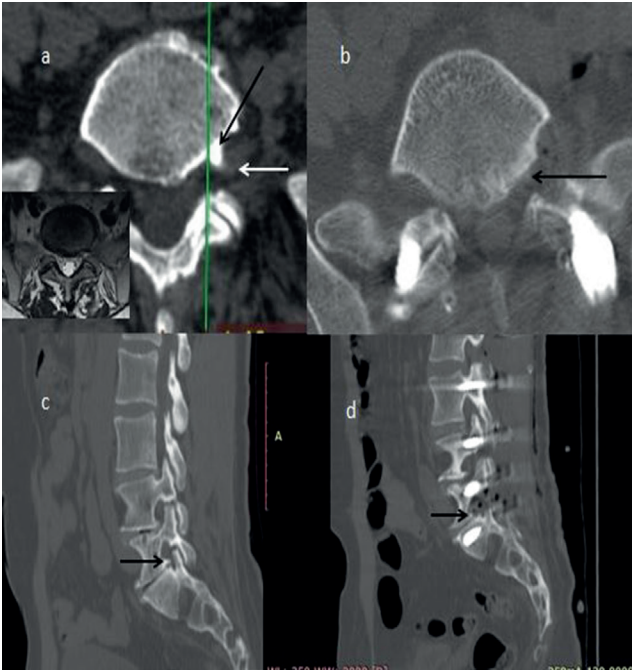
a) Axial magnetic resonance and computed tomography (CT) images show how the root (white arrow) was compressed by a grade 3 osteophyte (black arrow). CT image shows that this is purely osseous pathology. b) Black arrow in postoperative axial CT section shows decompression. An osteophytic spur can be seen on the lateral side of the vertical red line, (a) which crosses from the anterior point of the articulation faces of the facet joint. Facetectomy and osteophylectomy were performed for L5 root decompression. In addition to facetectomy, the patient was stabilized because of chronic low back pain. Black arrows in preoperative (c) and postoperative (d) sagittal CT sections show differences after surgical treatment. Left radicular pain completely regressed
